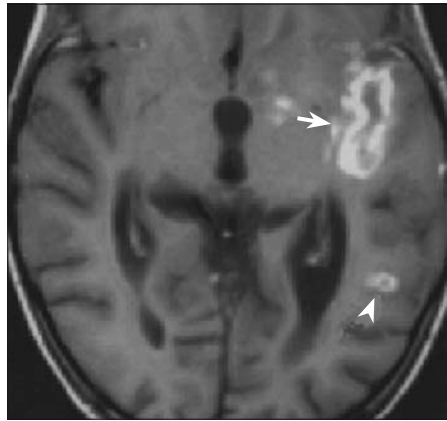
Central nervous system tuberculous meningitis. A postcontrast T1-weighted MR image demonstrates leptomeningeal enhancement along the left sylvian fissure (arrow). There is an accompanying ring-enhancing tuberculoma in the left parieto-occipital region (arrowhead). Reprinted with permission from *Radiographics* (1).
